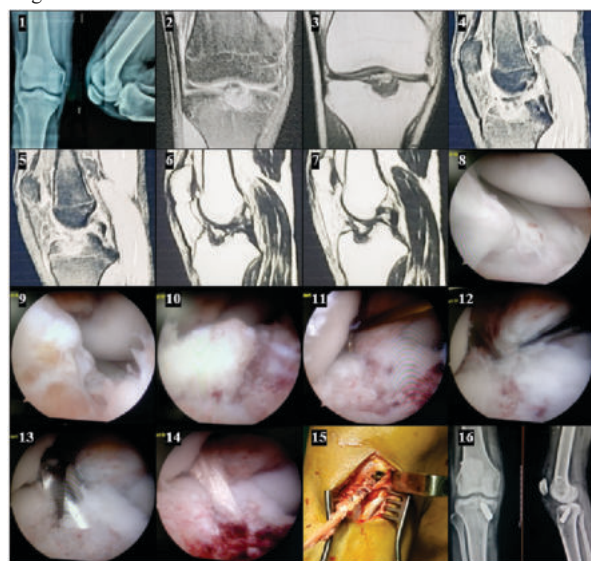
Image 1 shows x-ray of non-union of tibial spine fracture in a 19 year old male patient. Images 2-7 are of pre-operative MRI scan showing non-union of displaced tibial spine avulsion fracture and altered interstitial signal of ACL. Images 8-9 show arthroscopy finding of non-union of the displaced tibial spine avulsion fracture held to its
